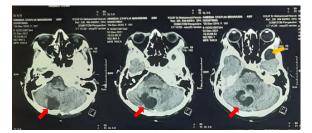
A head CT-scan first day after VP shunt removal. In axial plane, a fossa posterior mass was appeared in right hemi cerebellum (red arrow) and arachnoid cyst in left temporal (yellow arrow)
